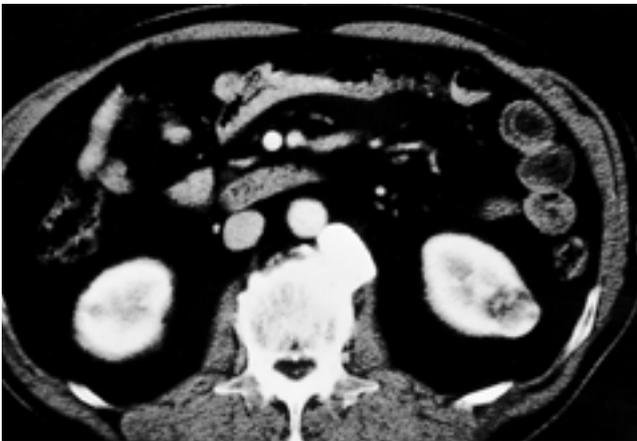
Post-enhanced CT shows 2 cm sized, heterogeneously low density nodule in left kidney. CT stage was T1 by old and new TNM classification and this tumor was 2.3 cm sized, pathologic stage T1 renal cell carcinoma.
